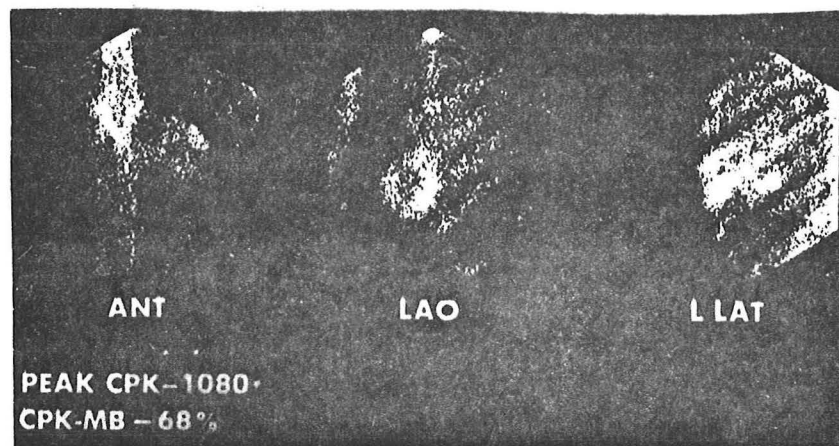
PYP scintigram of a non-Q-wave myocardial infarction (43).
